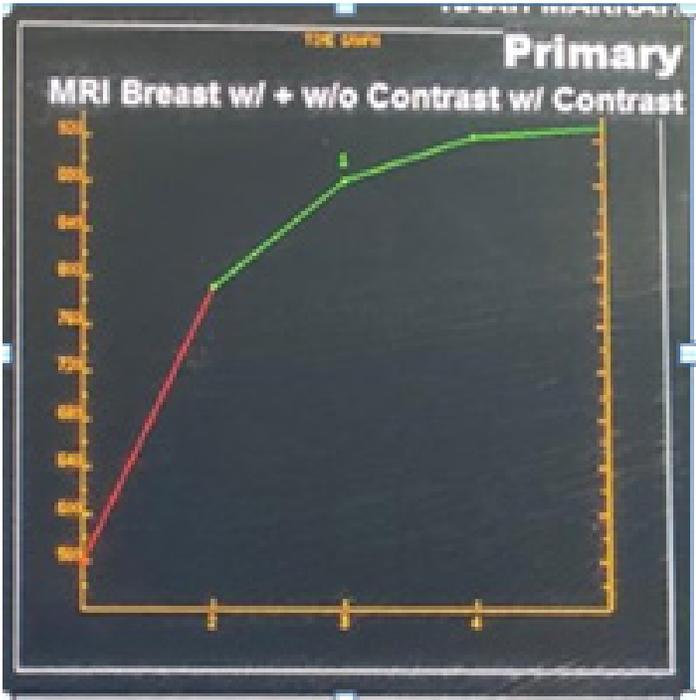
MRI time-intensity kinetic enhancement curve shows type II plateau. Biopsy results showed fat necrosis. No malignant pathology
